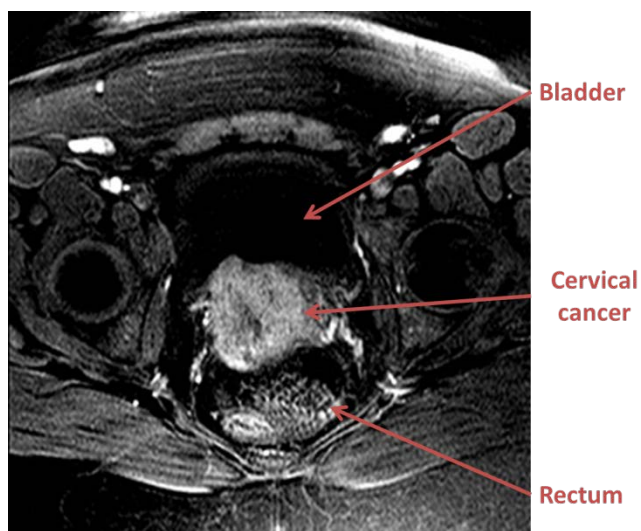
Axial contrast MRI. Stage IVa with bladder involvement resulting in hydronephrosis (not shown). University of Massachusetts Medical School, Department of Radiology.
